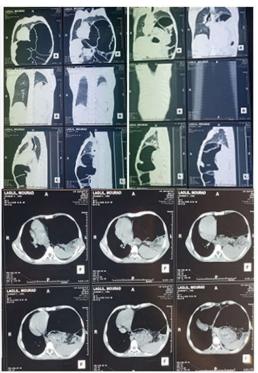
Chest CT scan (scout view): diminished pulmonary volume in the left hemithorax and herniation of stomach and colon. Chest CT scan (axial view): absence of left hemidiaphragm and herniation of stomach, small bowel, colon and spleen.
